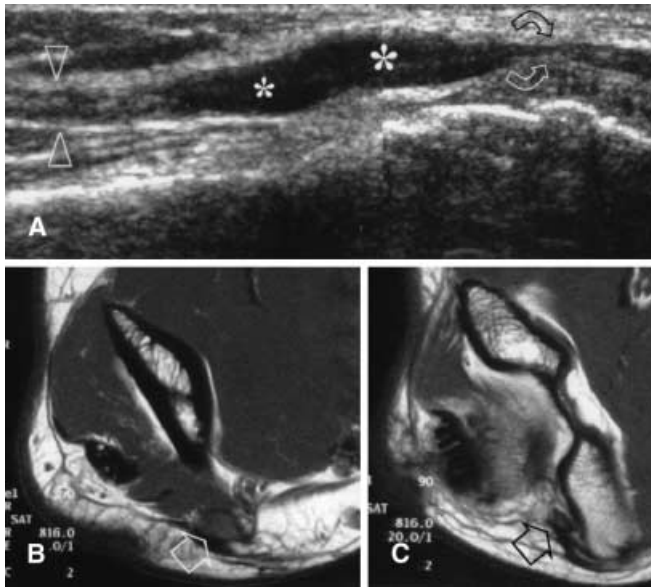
Cubital tunnel syndrome. A Longitudinal 12–5MHz US scan of the cubital tunnel in a patient with cubitus valgus demonstrates the ulnar nerve (*arrowheads*) which appears increasingly swollen and hypoechoic (*asterisks*) as it progresses towards the compression point (*curved arrows*). B, C Transverse T1-weighted (TR/TE 816/20 ms) correlative MR images obtained at the distal arm (B) and within the cubital tunnel (C) show the abrupt change in the cross-sectional area of the nerve (*arrow*)
